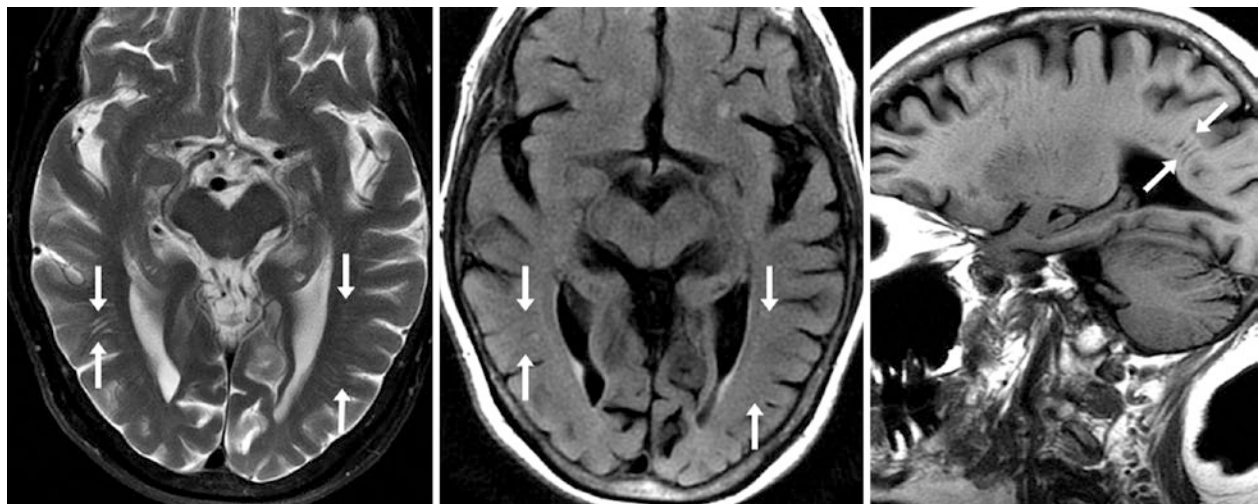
A 73 year old had bilateral PVSs located within the deep temporal white matter (*between arrows*). The PVSs are ovoid, radiating foci on T2WI (*left*) that suppress on FLAIR (*middle*). They appear linear on sagittal T1WI (*right*)
